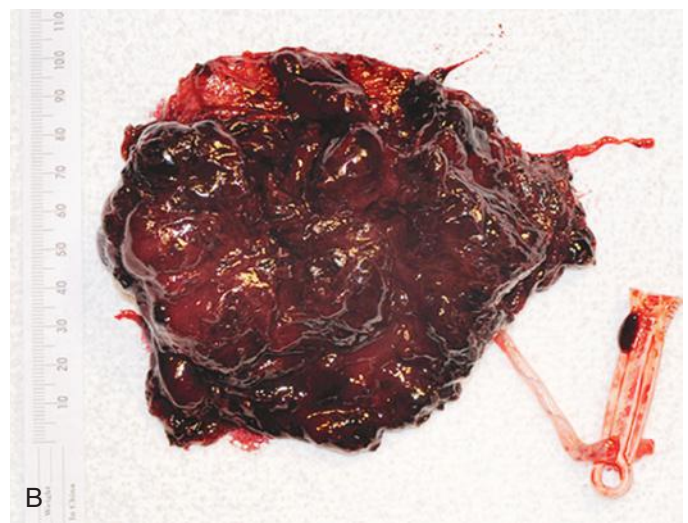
Placental abruption. A, This patient presented at 16 weeks with vaginal bleeding and pain. The placenta appears thickened and inhomogeneous. The fetus died during the sonogram. B, At delivery, more than 90% of the placenta was covered with adherent clot.
